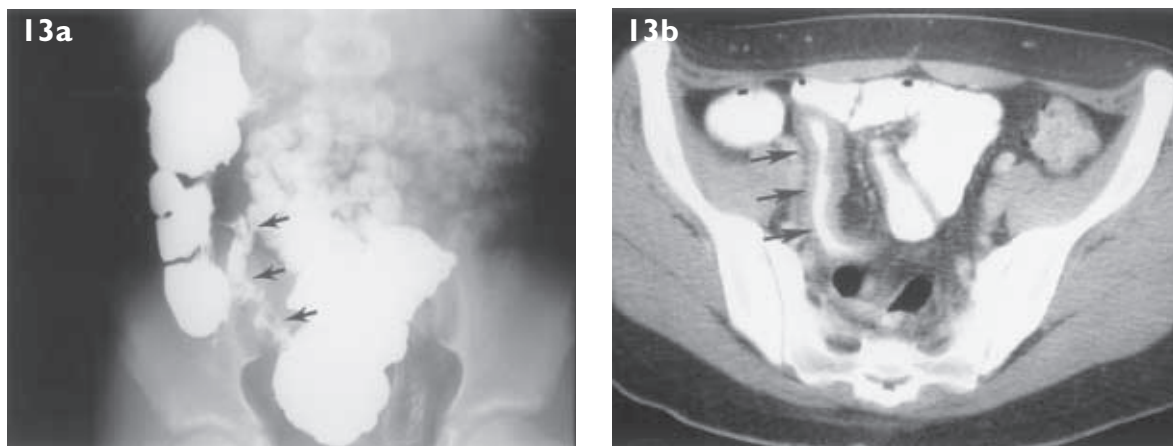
Crohn's disease. A) Small bowel follow-through with barium shows irregularity and nodularity of the terminal ileum (arrows). B) On CT, bowel wall thickening of the terminal ileum (arrows) is seen.
